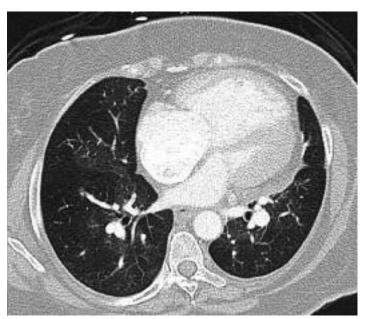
Computed tomographic image of lungs showing patchy ground glass densities in a patient with severe PH and sarcoidosis with stage 0 chest radiograph.
